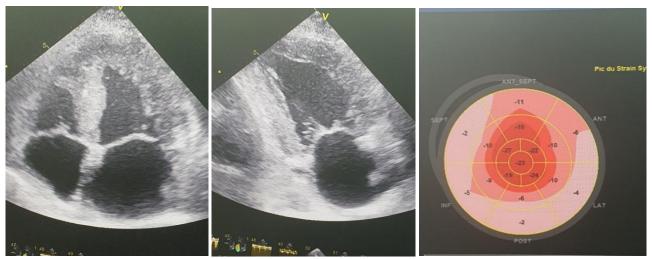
Transthoracic echocardiography: showing left ventricular hypertrophy and moderately altered global longitudinal strain (-13.2%) with an apical sparing pattern
